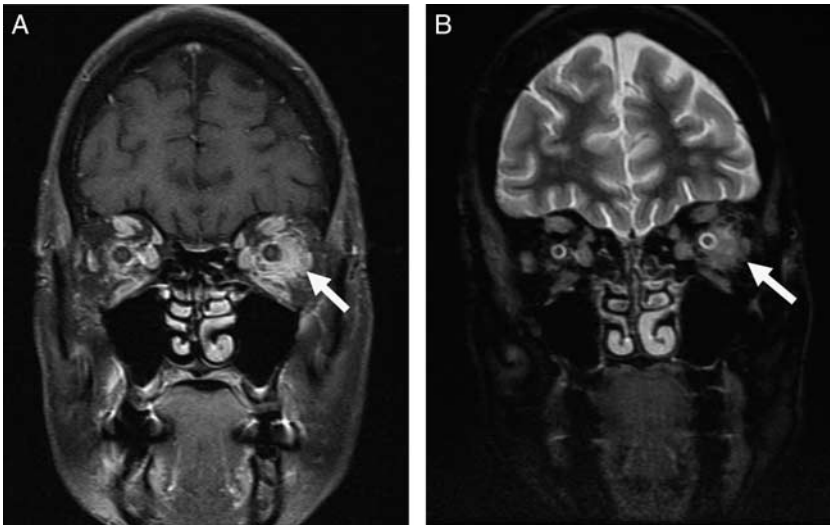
64-year-old woman with metastatic breast cancer developed headaches and diplopia. MRI demonstrates breast cancer metastases to the orbits. Coronal T1-weighted fat saturation postcontrast MRI demonstrates irregular enhancing intraconal soft tissue as well as abnormal enhancement of the bilateral optic nerves (A, white arrow). Coronal T2-weighted MRI demonstrates T2 hyperintensity surrounding the left greater than right optic nerves (B, white arrow). MRI indicates magnetic resonance imaging.
